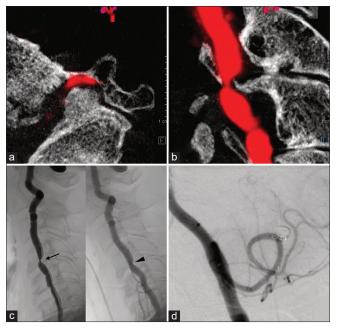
Intraoperative computed tomography and angiography findings. (a) Sagittal and (b) axial cone-beam computed tomography images show osteophyte compression-induced left vertebral artery (VA) stenosis at the C4–5 level. (c) Angiography of the left VA with slight neck extension shows stenosis of the VA (left panel, arrow); however, the stenosis improves when the neck is flexed (right panel, arrowhead). (d) Postoperative angiography of the VA shows complete obliteration of the aneurysm.
